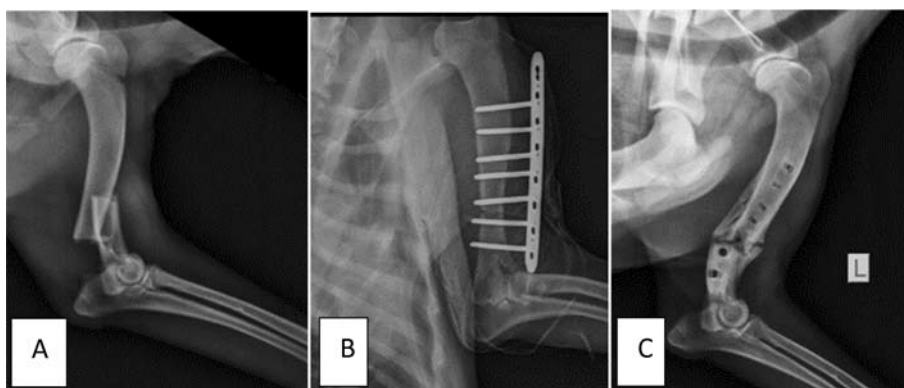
(A) Preoperative radiograph (B) Immediate postoperative radiograph (C) Radiograph after implant removal
